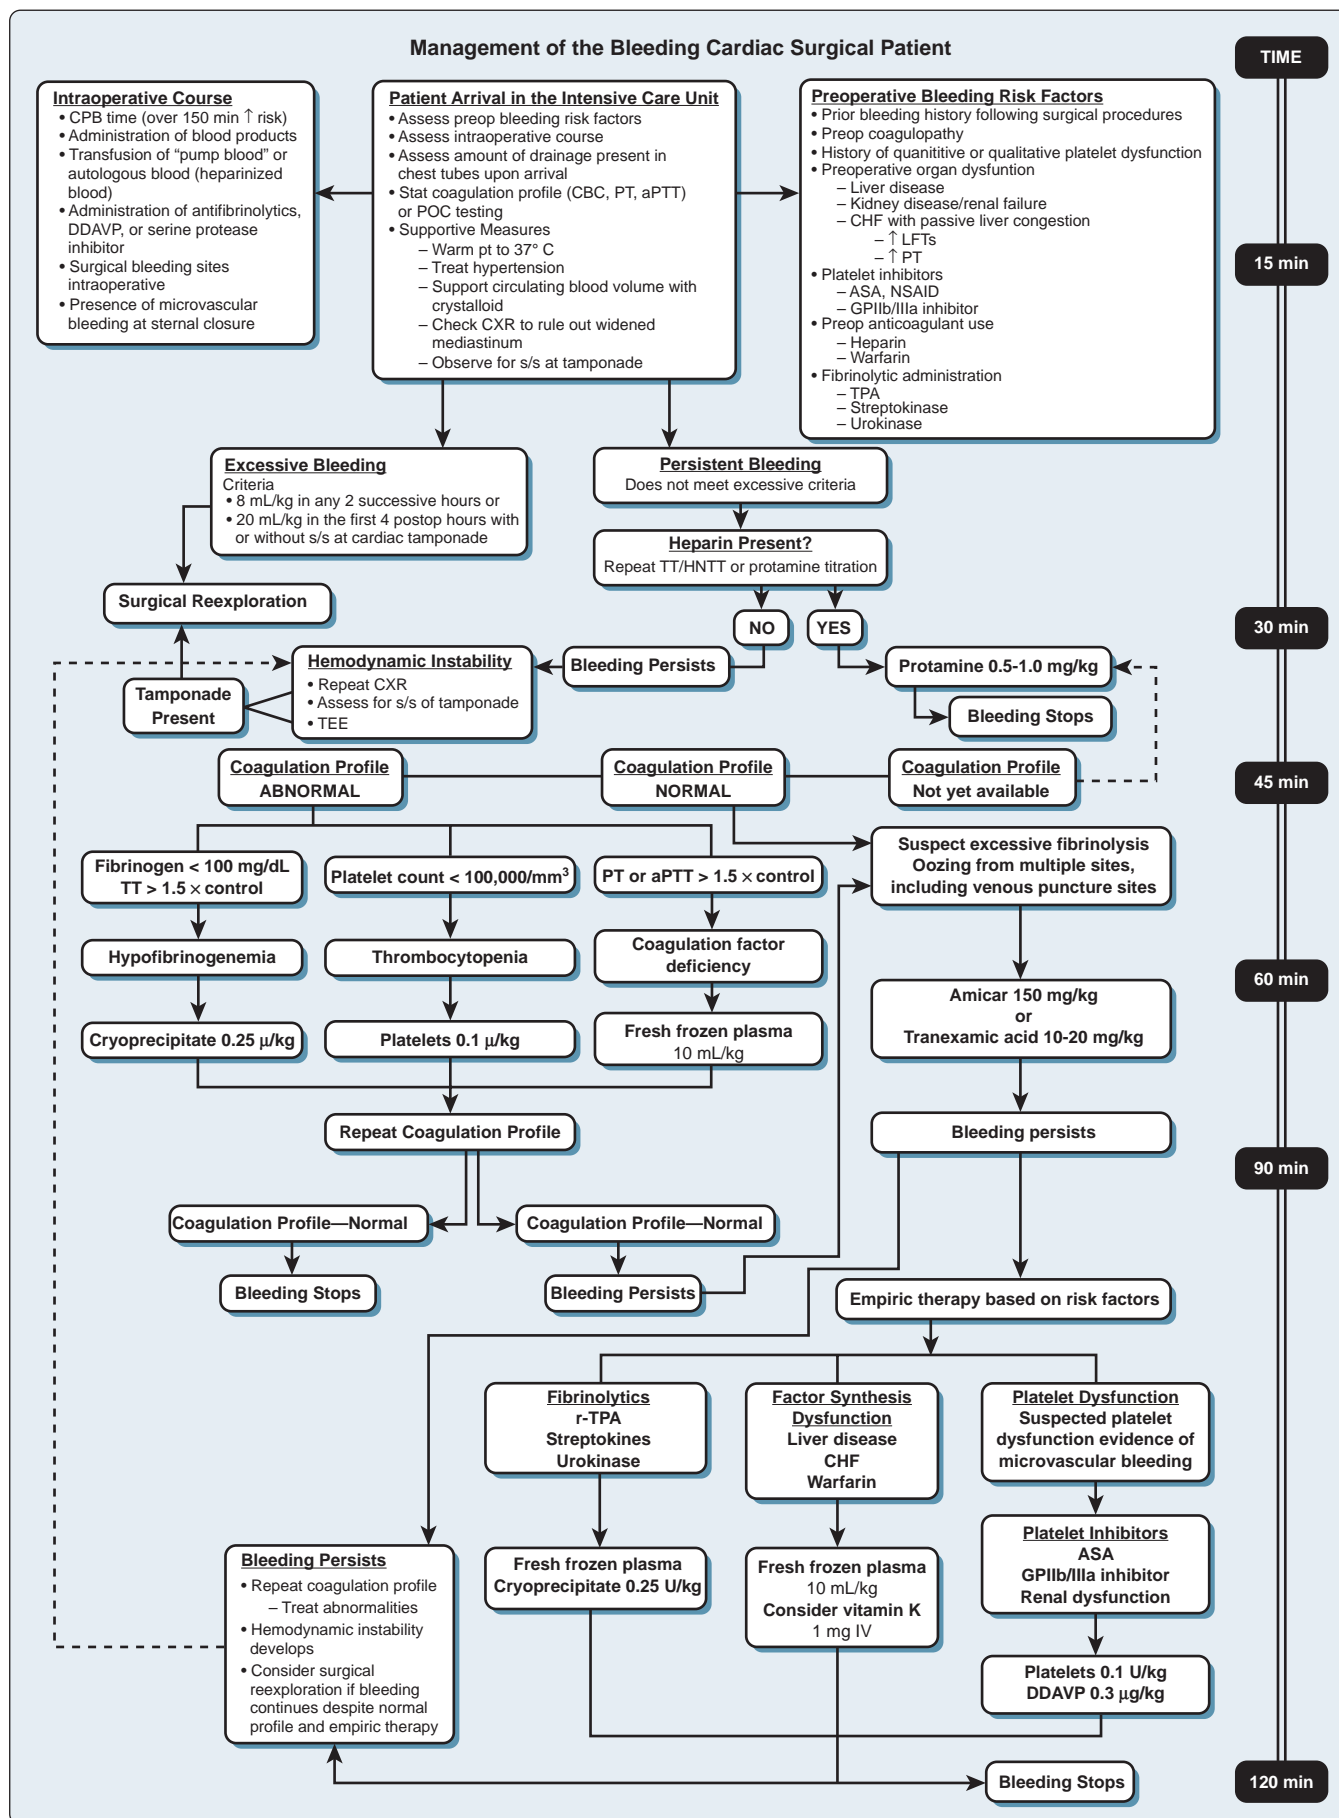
Example of a scheme for treating excessive bleeding. aPTT, Activated partial thromboplastin time; ASA, acetylsalicylic acid; CBC, complete blood cell count; CHF, congestive heart failure; CPB, cardiopulmonary bypass; CXR, chest radiograph; GP, glycoprotein; NSAID, nonsteroidal antiinflammatory drug; POC, point of care; PT, prothrombin time; r-TPA, recombinant tissue plasminogen activator; TEE, transesophageal echocardiography; t-PA, tissue plasminogen activator. (From Milas B, Johes D, Gorman R. Management of bleeding and coagulopathy after heart surgery. Semin Thorac Cardiovasc Surg. 2000;12:326.)
